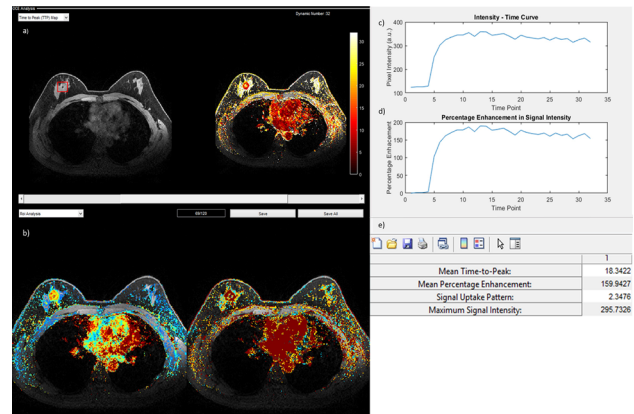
A sample DCE-MRI analysis. a) Original MRI (left) with TTP map (right). b) PE map (left), and the signal uptake map showing washout, plateau or persistent patterns (right). c,d) Kinetic curves, and e) calculated parameters of defined ROI.
